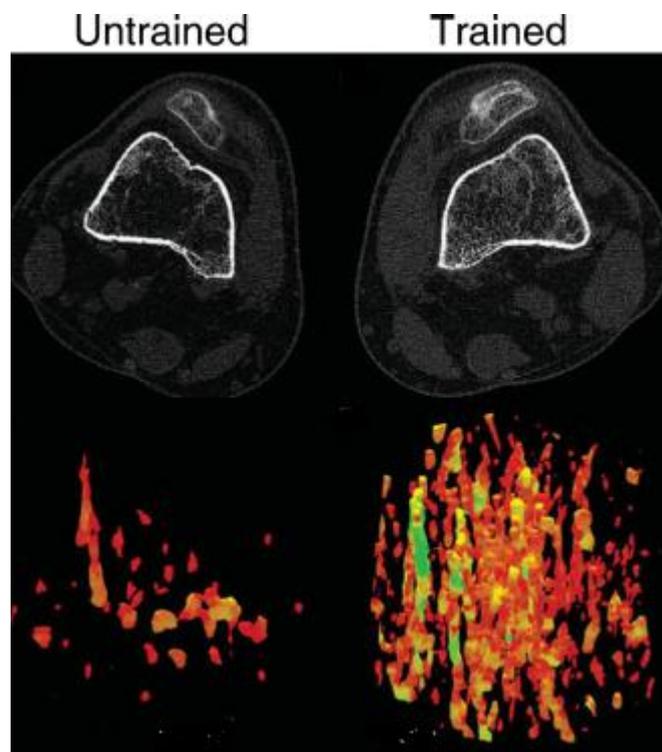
Upper panel: CT images of an untrained (left) and trained (right) limbs at 12% of the femur length. Lower panel: 3D reconstruction of the trabecular lattice at the same region showing the greater loss in the untrained compared to the trained limb[170]
